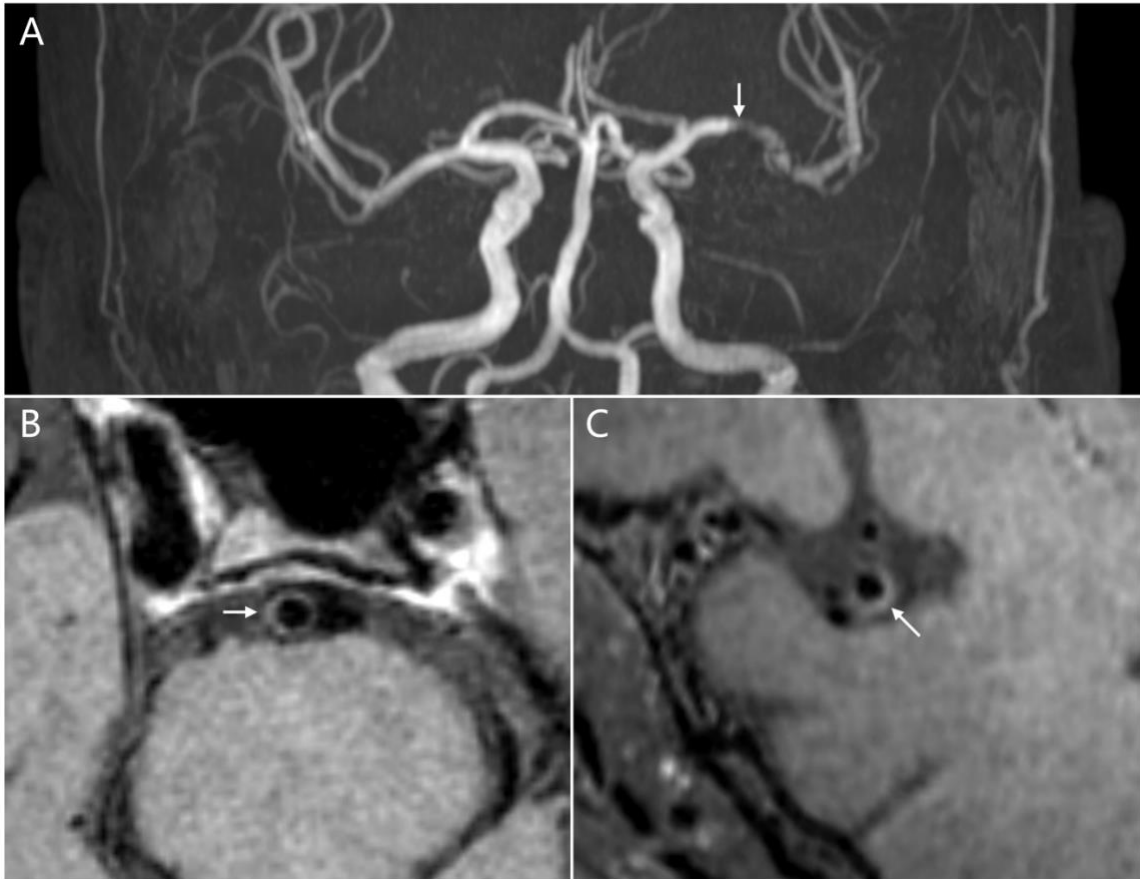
A 63-year-old male patient with acute infarction due to atherosclerotic stenosis of the left MCA-M1 segment. A, a symptomatic atherosclerotic stenosis of the left MCA-M1 segment on the MRA image (white arrow). B, an eccentric, focal plaque in the BA as an asymptomatic atherosclerotic lesion on the T1w image (white arrow). C, an eccentric, focal plaque in the MCA-M2 segment as an asymptomatic atherosclerotic lesion on the T1w image (white arrow). BA, basilar artery; MCA, middle cerebral artery; MRA, magnetic resonance angiography; T1w, T1-weighted.
